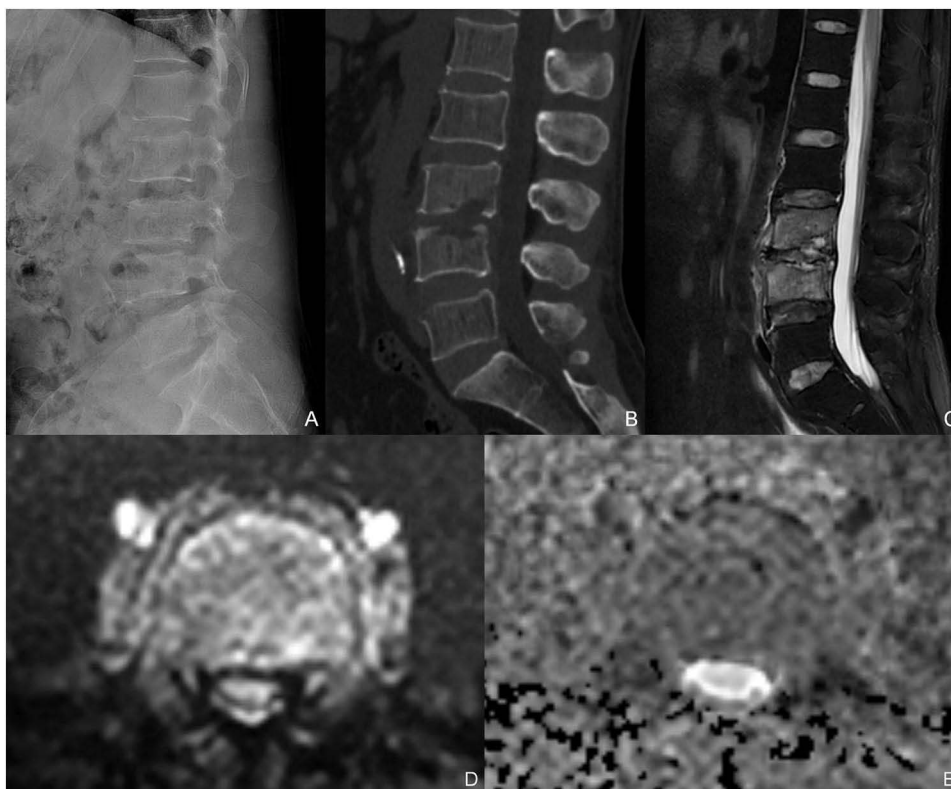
A 46-year-old male was diagnosed with early-stage BS. X-ray diagnosis showed degenerative lumbar bone disease (A); sagittal CT scan reconstruction demonstrated bone destruction below the endplate of the lumbar vertebrae 3 and 4, with clear boundaries and no sclerotic edges (B); MRI scan with fat-suppressed T2 weighted image (T2WI) sequence showed high signal bone destruction under the endplate of the lumbar vertebrae 3 and 4, and surrounding bone marrow edema (C); Axial lumbar Diffusion weighted imaging (DWI) with b-value=600, showing restricted diffusion with hyperintense signal in the paravertebral abscess (D); Axial lumbar Apparent Diffusion Coefficient (ADC) map, demonstrating hypointense signal in the abscess with restricted diffusion, with ADC values approximately $0.6\text{--}1.0\text{ mm}^2/\text{s}$ (E).
